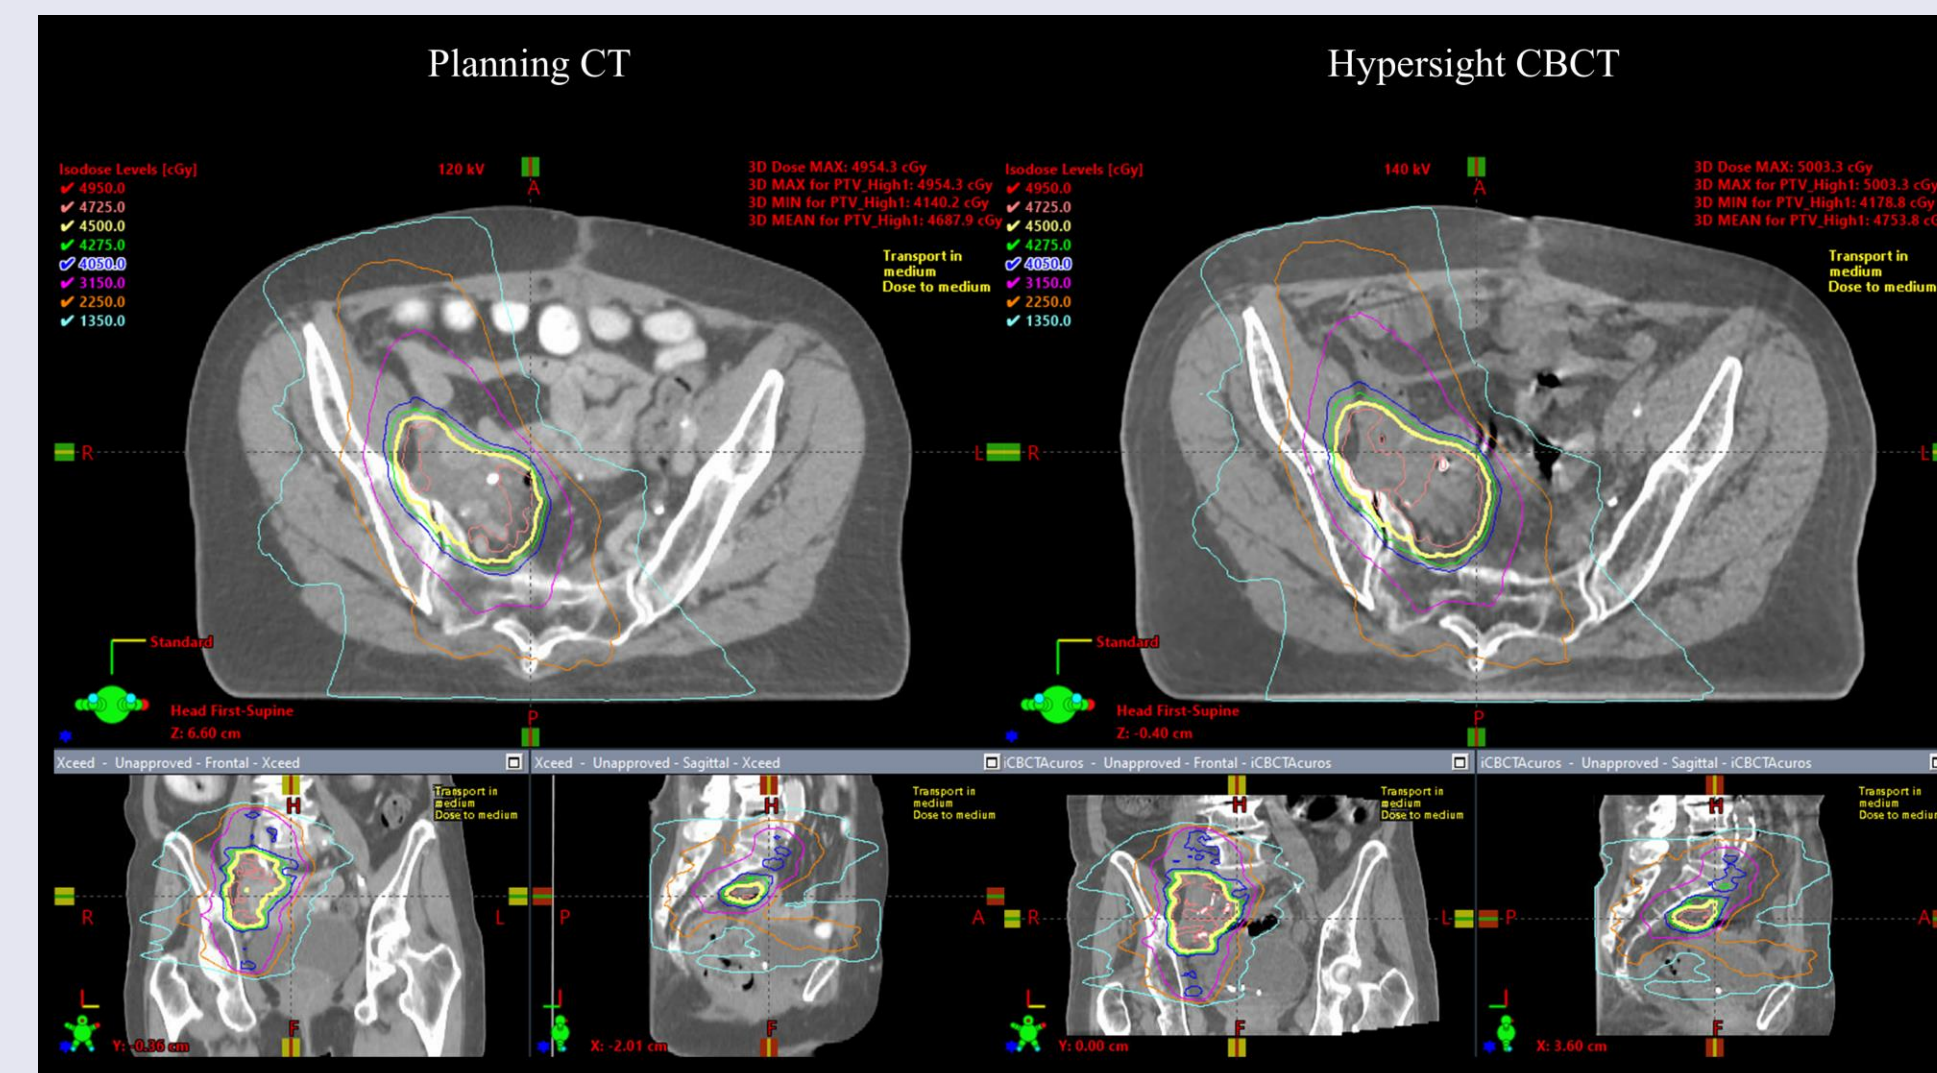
Isodose line comparison for plan calculated on planning CT and HyperSight CBCT on axial view for one clinical case.
